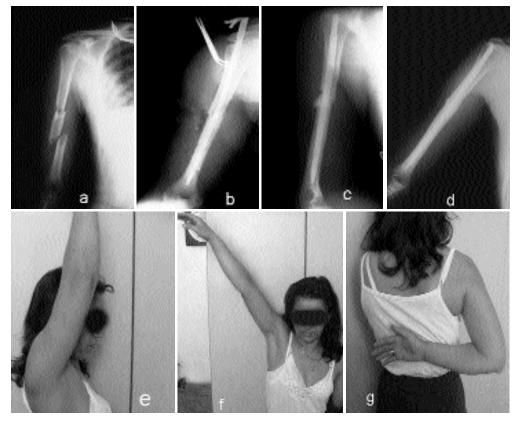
(a) 34 years old female with 12 C2 fracture preoperatively. (b) peroperative radiograph before nail inflation. (c) early postoperative and (d) 1 year postoperative radiographs. (e, f, g) at one year functional results with full shoulder range of motion.
